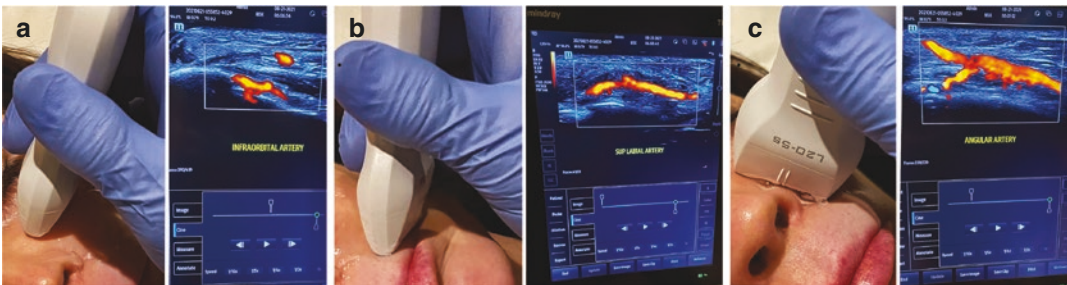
(a–c) US can be used for precision-guided facial autologous biological injections locating critical arteries, veins, and nerves using duplex sonography
